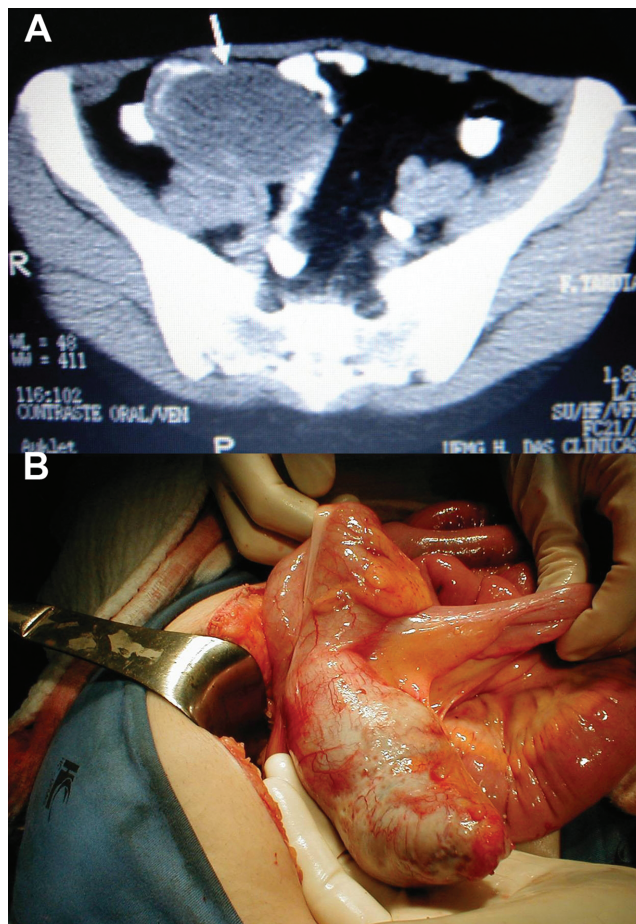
A) CT scan showing a well-encapsulated cystic mass in the right lower quadrant (arrow); B) Mucocele of the appendix.
